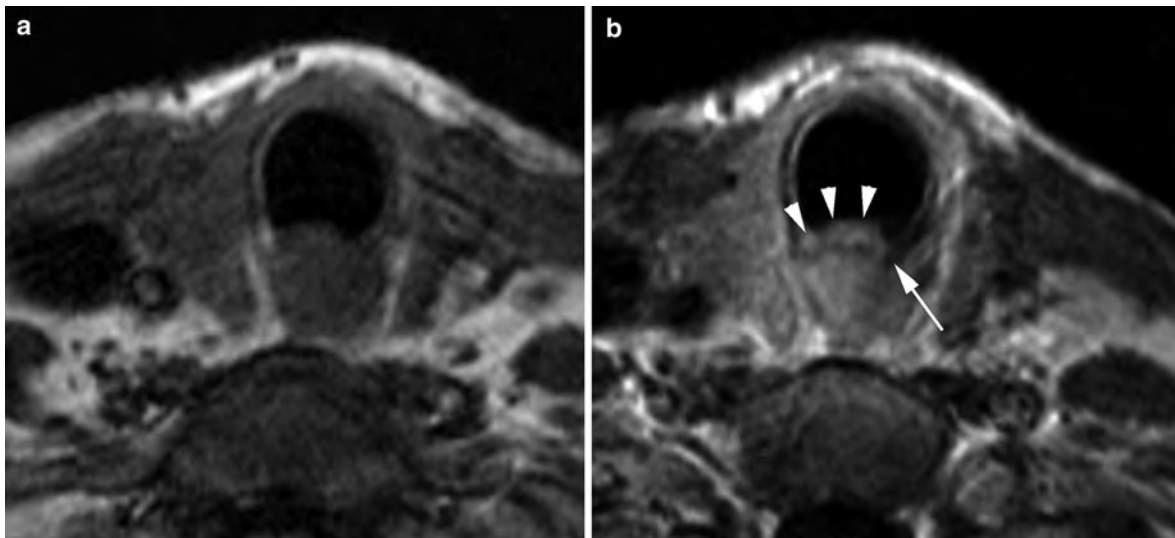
Axial non-enhanced T1- (a) and contrast-enhanced T1- (b) weighted images through the upper esophagus show lack of patent esophageal lumen caused by an esophageal cancer that is difficult to appreciate on the non-enhanced T1-weighted image (a). The contrast-enhanced T1-weighted image
